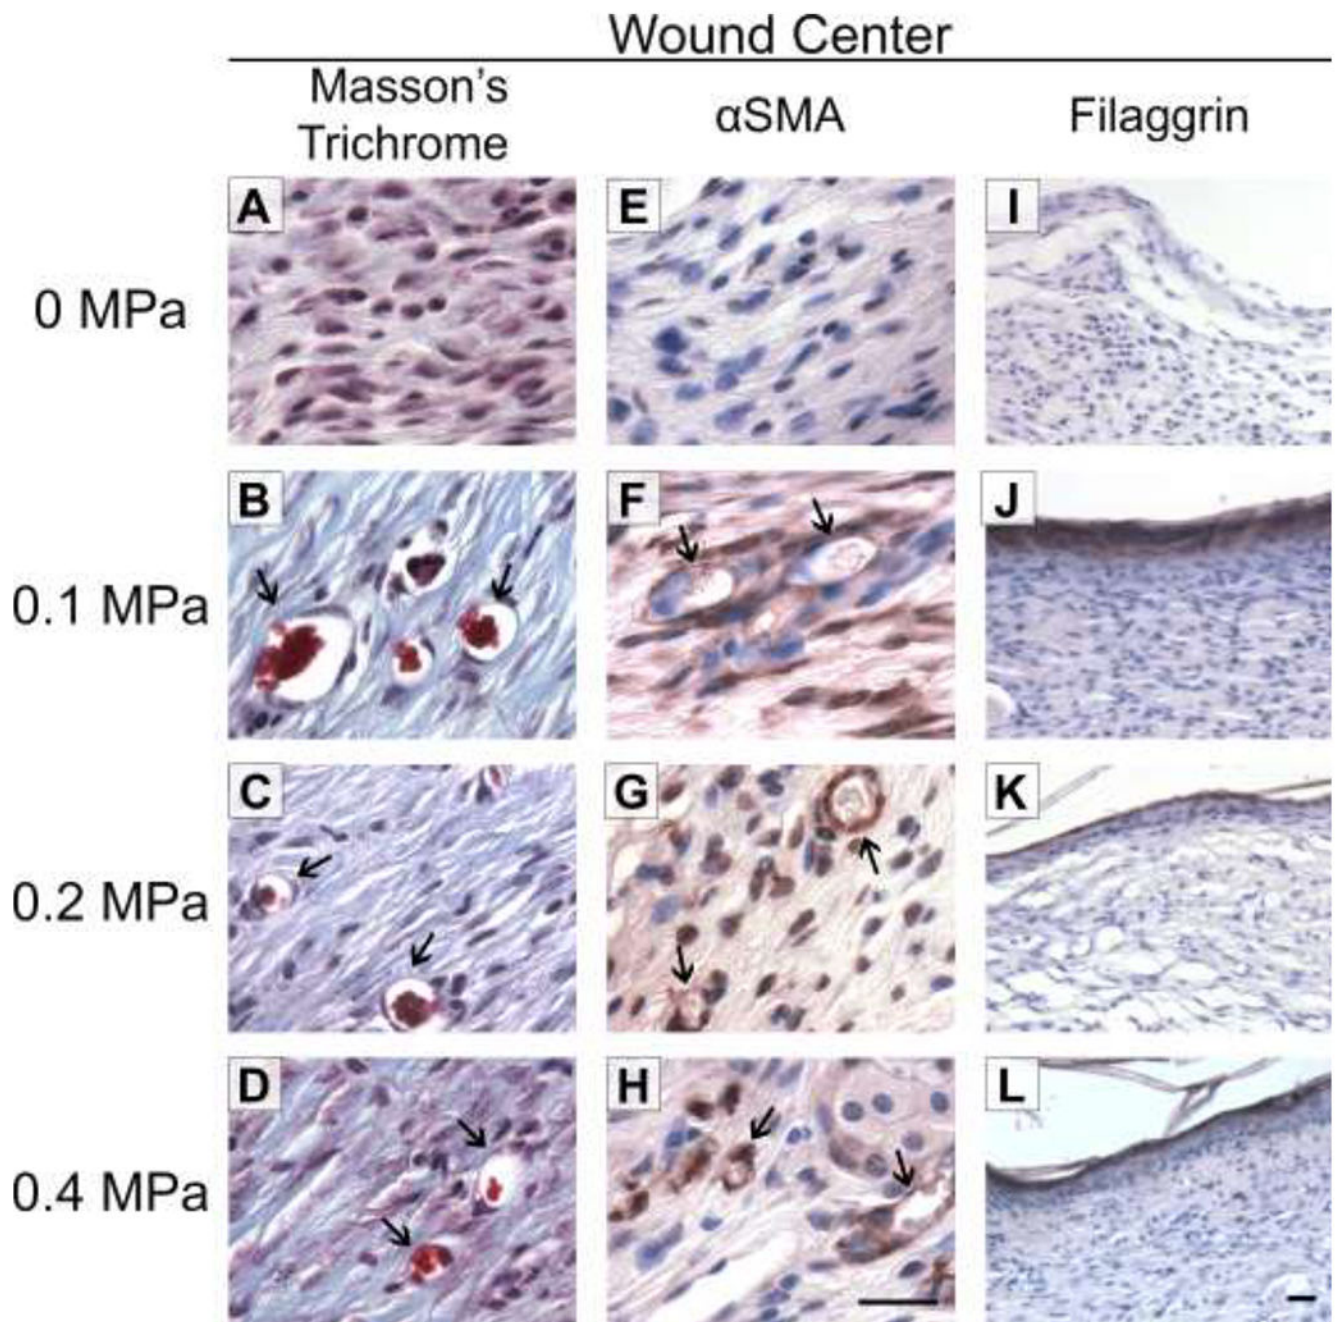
Re-vascularization and epidermal maturation of ultrasound-exposed wounds
